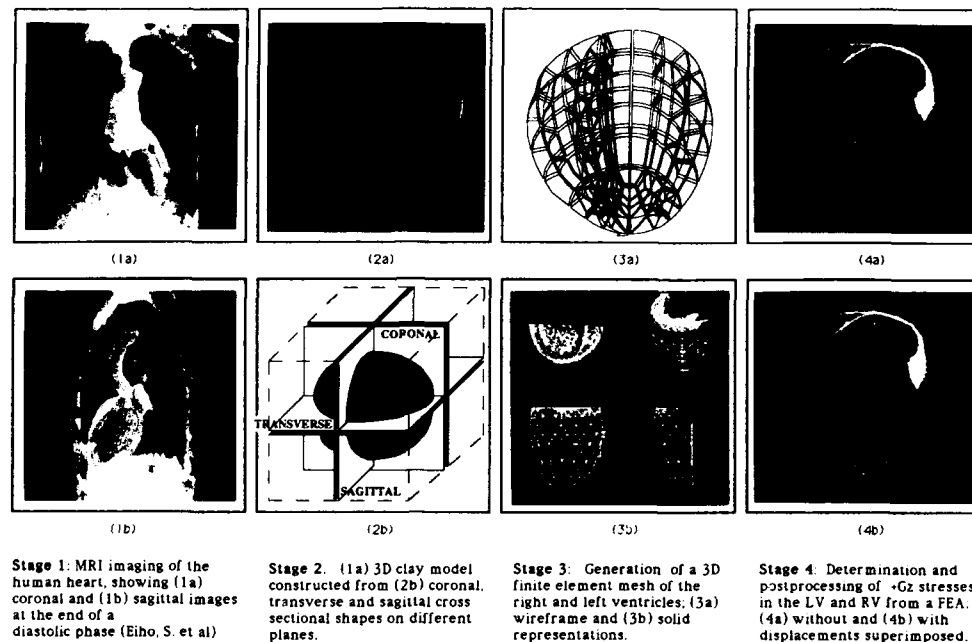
MRI imaging, FE modeling and analysis of the human left and right ventricles.
